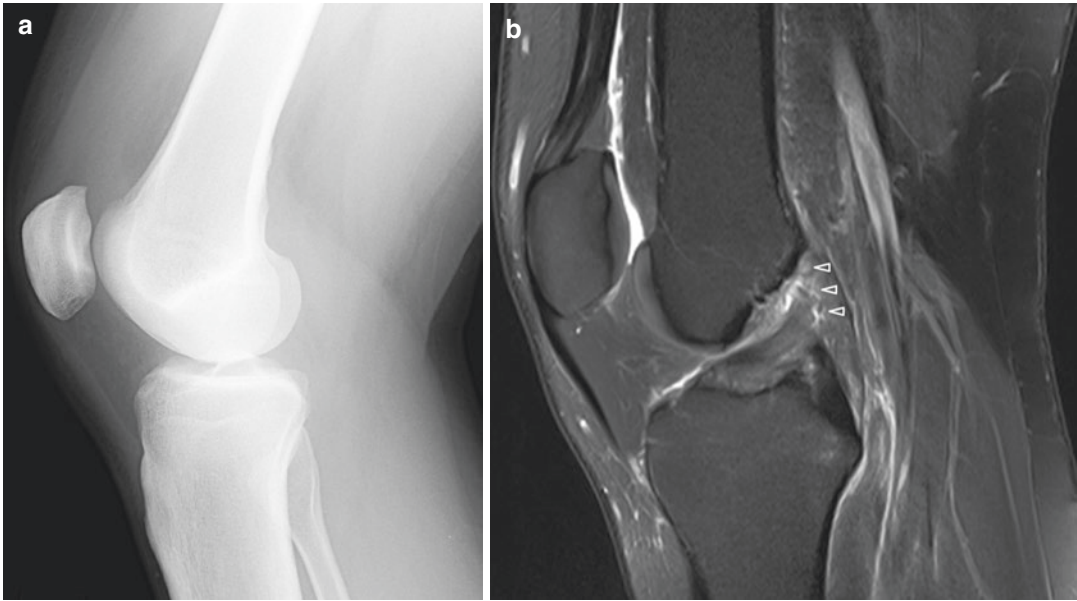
A 35-year-old man who presented with right knee pain after a twisting injury sustained during a game of basketball. (a) Lateral radiograph of the right knee shows no significant bony injury or joint malalignment. A small suprapatellar joint effusion is noted. (b) Sagittal fat-suppressed PD-W MR image of the right knee shows a
